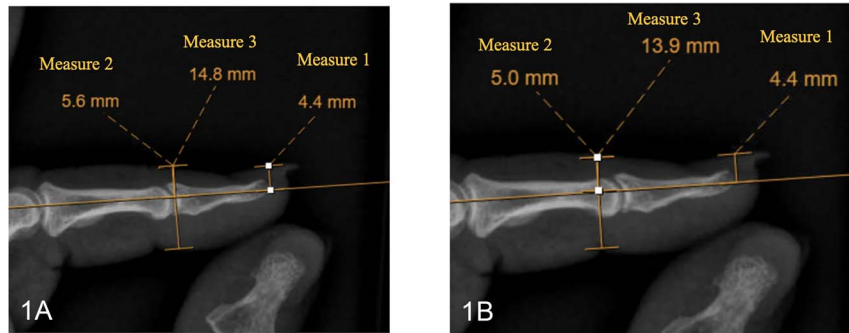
Radiographic measurements performed. Measure 1: distance from nail plate to ideal line; measure 2: distance from dorsal surface soft tissue to ideal line (1A = DIPJ; 1B = DIPJ volar crease); measure 3: total soft tissue sagittal diameter (1A = DIPJ; 1B = DIPJ volar crease).
